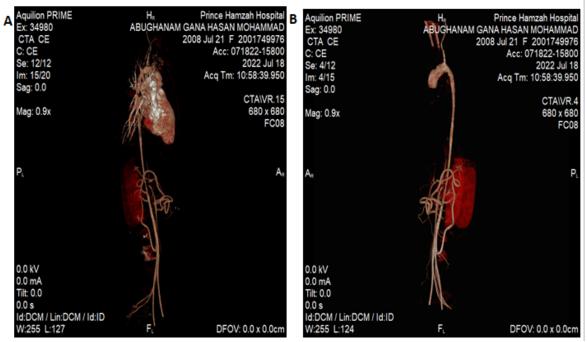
CT angiogram of the aorta, A+B, showed that the descending thoracic aorta from the isthmic segment through the abdominal aorta is diffusely hypoplastic with a diameter of 6 mm.
